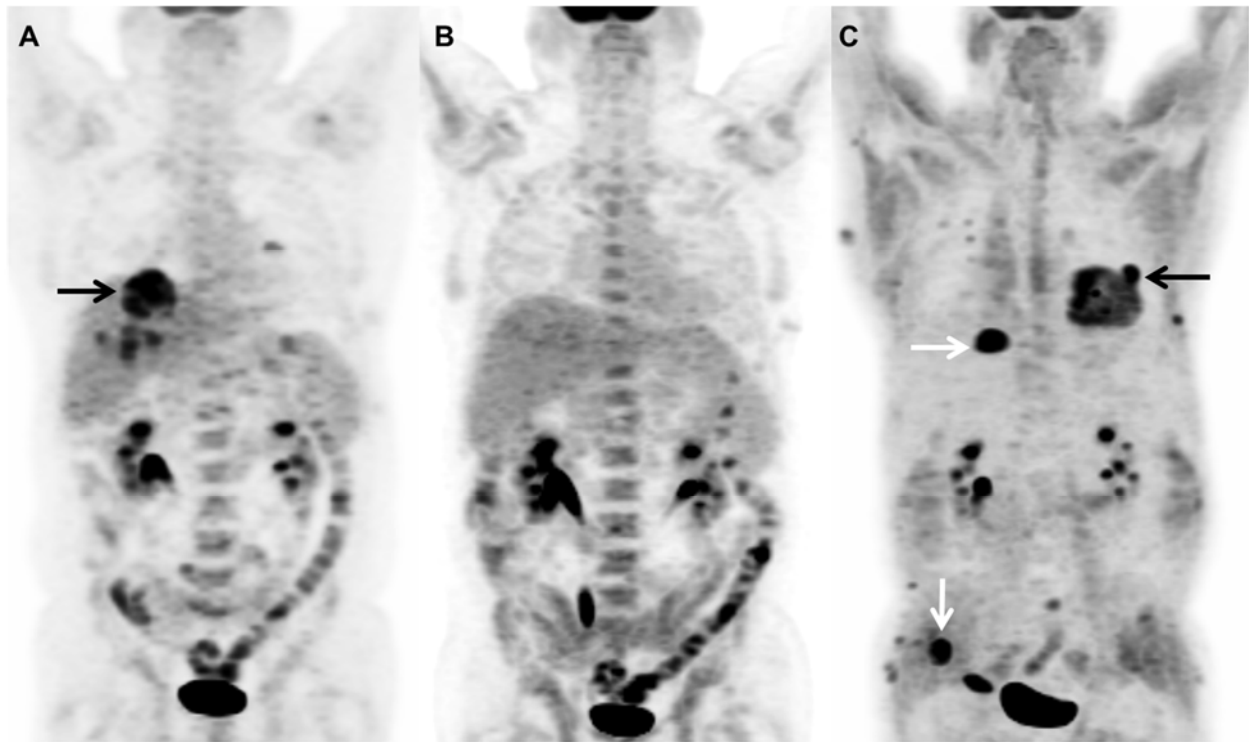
Staging 18F-FDG PET/CT showed multiple hypermetabolic lung lesions (arrow in A). After 6 cycles of R-CHOP therapy, all lesions resolved (B). Seven months later, a re-staging 18F-FDG PET/CT (C) showed recurrent multiple subcutaneous hypermetabolic lesions (white arrows) and one left lung hypermetabolic nodule (black arrow).
